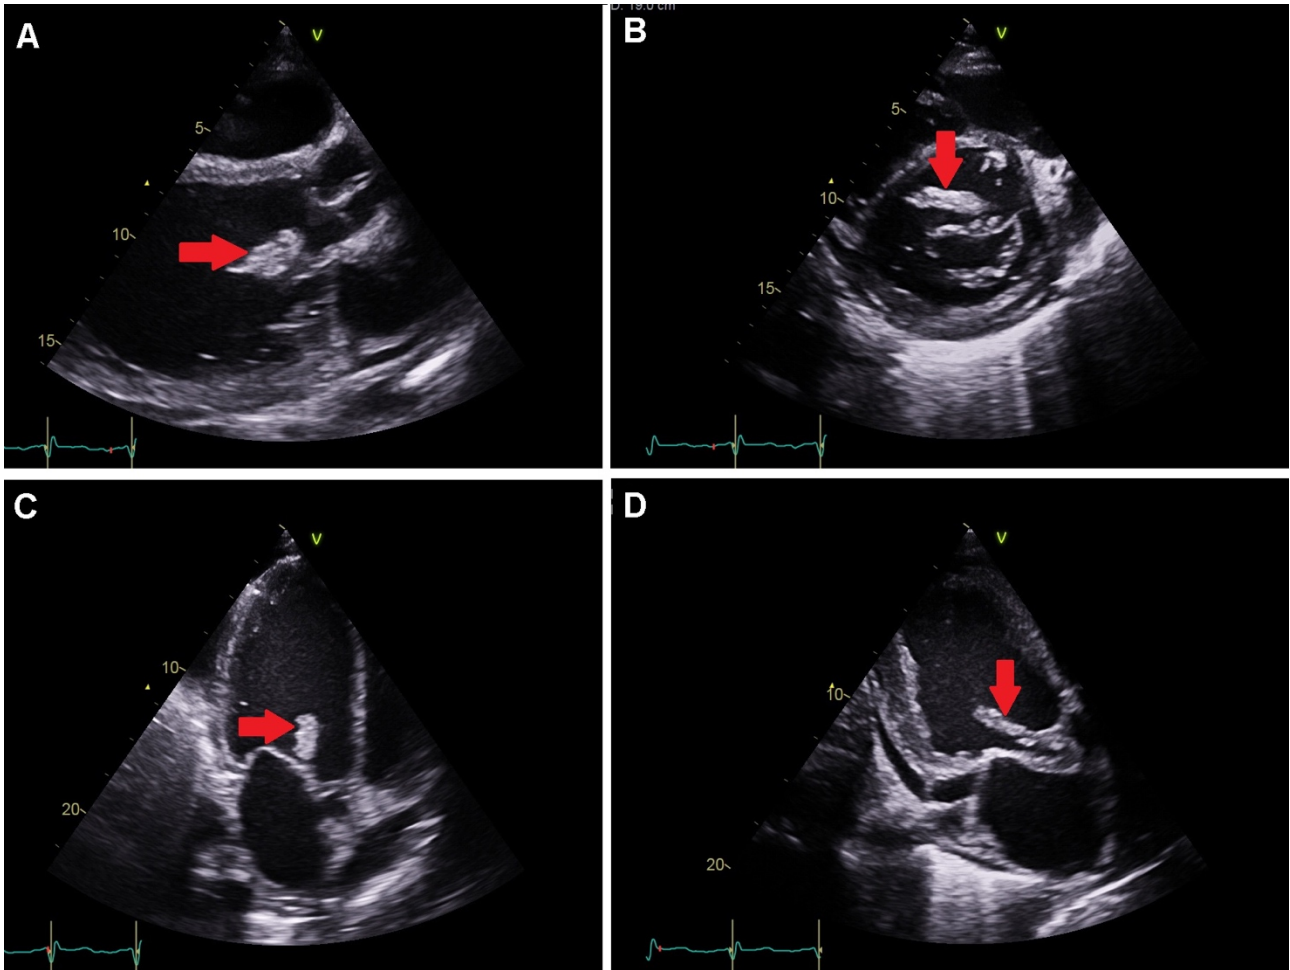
Transthoracic echocardiographic examination, 2D imaging: A — Long-axis parasternal view, B — Short-axis parasternal view, C, D — Apical views C — Three-chamber, D — Modified. A red arrow indicates a structure with variable echogenicity corresponding to bacterial vegetation.
